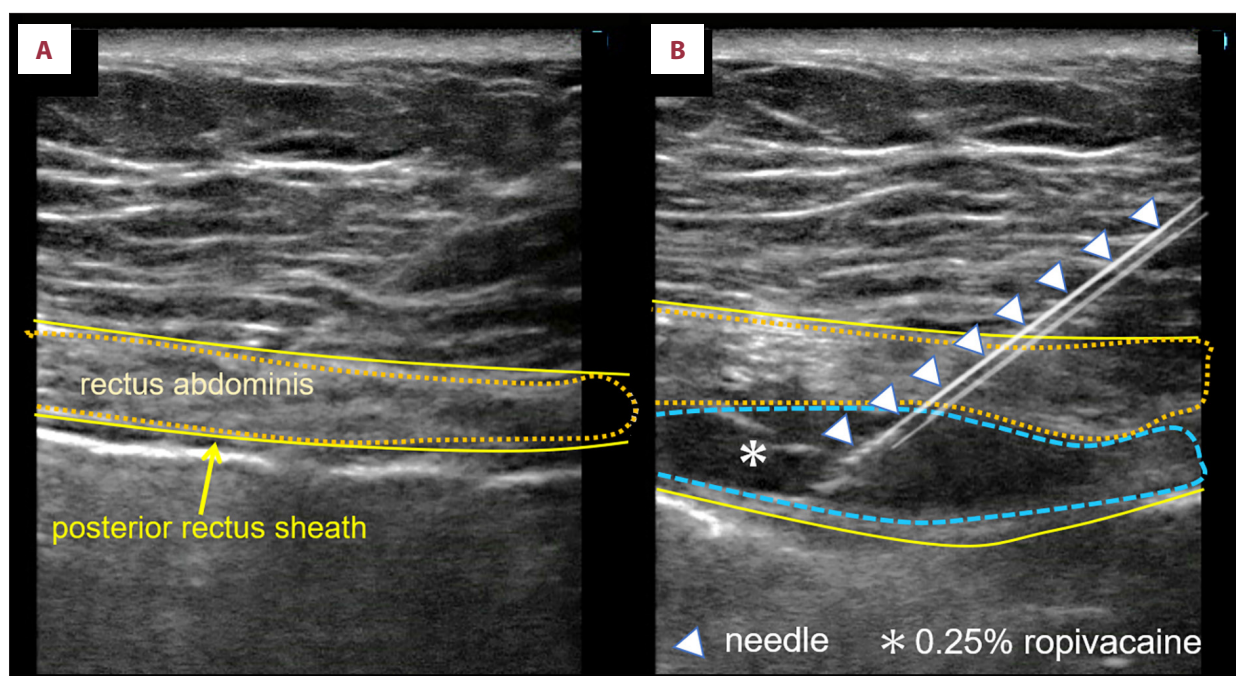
Ultrasound-guided rectus sheath blocks at the points of tenderness. (A) Ultrasound image of the rectus abdominis and posterior rectus sheath. (B) Hydrodissection was performed between the rectus abdominis muscle and the posterior rectus sheath using an in-plane approach from lateral to medial for the rectus sheath blocks.
